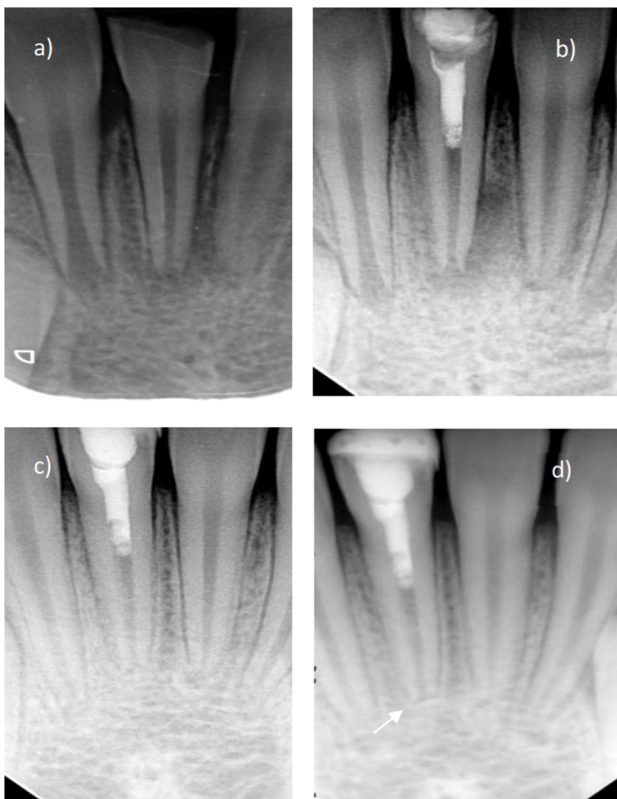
Thickening of the canal walls, closure of the apex, but no elongation of the root. a) Initial state; b) Radiography immediately after revascularization; c) Follow-up after 6 months; d) Follow-up after 18 months with thickening of the canal walls and closure of the apex (arrow).
